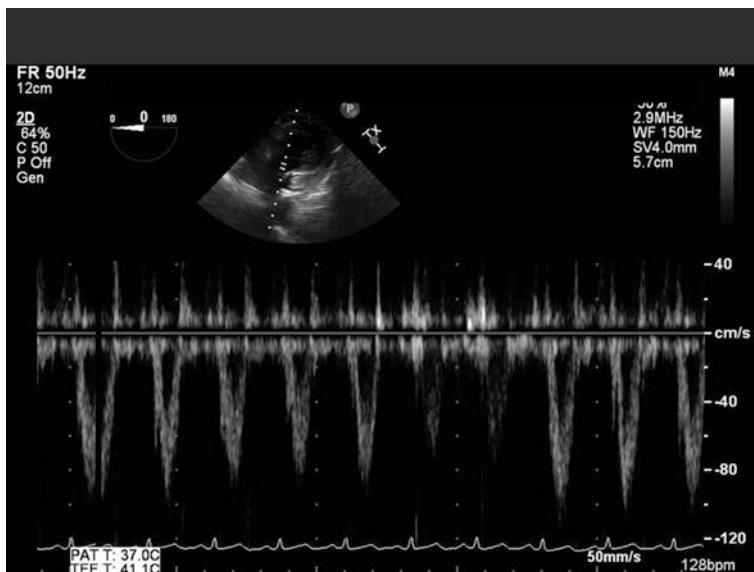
Deep transgastric long axis view with pulse wave Doppler placed in the left ventricular outflow tract showing respiratory variability
